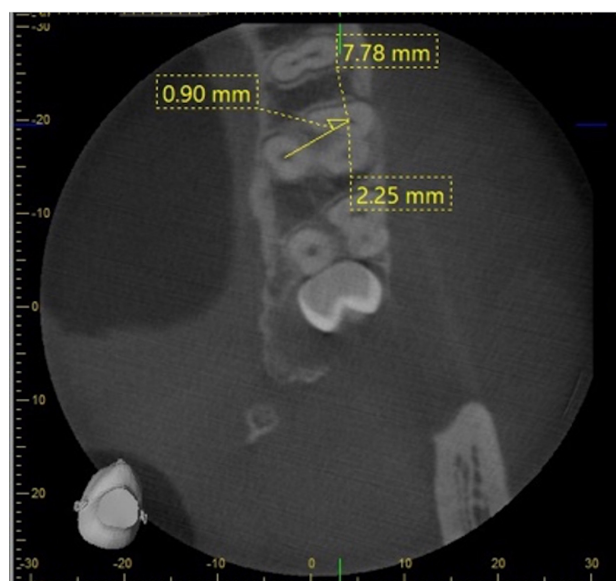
CBCT images of maxillary first molars on the J Morita software's main interface. The coronal view (1A), sagittal view (1B), axial view (1C), and 3-dimensional view (1D). The measuring plane's location is indicated by the red line.
